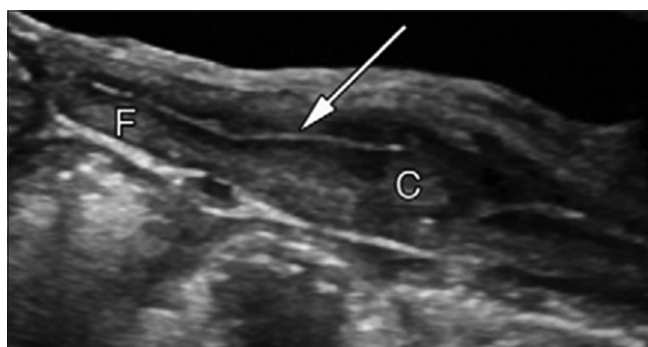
The sagittal ultrasound image of the neonatal uterus shows that the anteroposterior diameter of the cervix (c) is larger than that of the fundus (f). The endometrial cavity is seen as a thin echogenic line in the middle of the uterus (arrows) [24]
